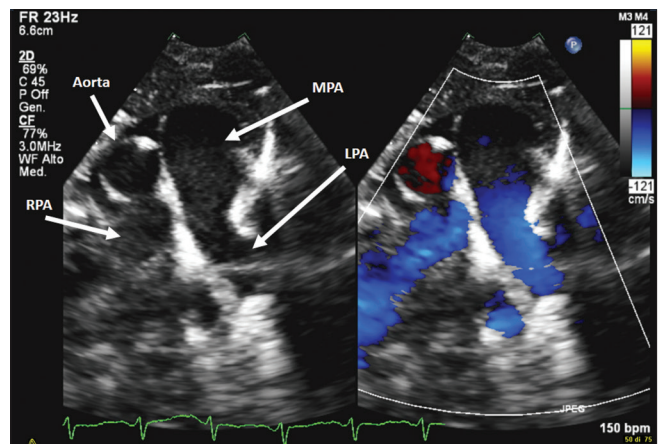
Preoperative echo short-axis parasternal view. MPA: Main pulmonary artery, LPA: Left pulmonary artery, RPA: Right pulmonary artery, aorta
